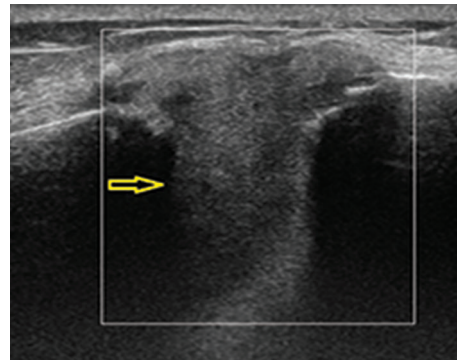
Ultrasound of a bone lesion (Gaucheroma) without Doppler signal.
